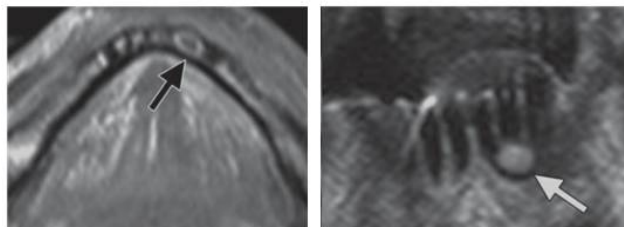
periapical cyst. (A) Axial gadolinium-enhanced fat-suppressed T1-weighted image shows enhancement of cyst wall (arrow); this finding is consistent with periapical cyst. (B) Coronal T2-weighted MR image shows high signal in anterior body of mandible (arrow).
